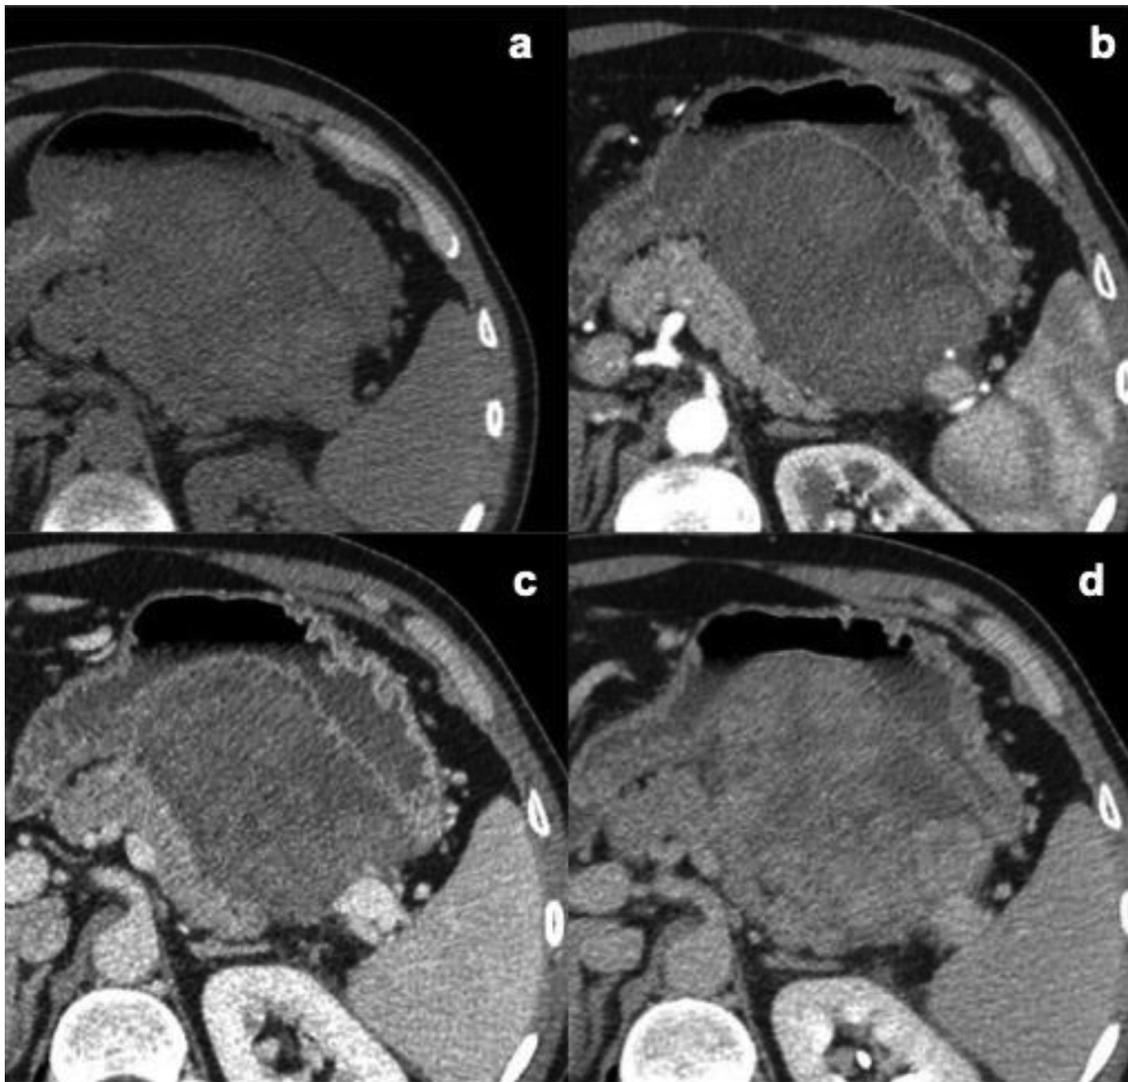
Solitary fibrous tumor in a 55-year-old male patient. Precontrast (a) and contrast-enhanced (b-d) CT images show a large well-delineated lesion of the pancreatic body, presenting with progressive enhancement from the arterial (b) to portal (c) and delayed 3' (d) phases. The lesion was resected confirming the diagnosis of solitary fibrous tumor.
